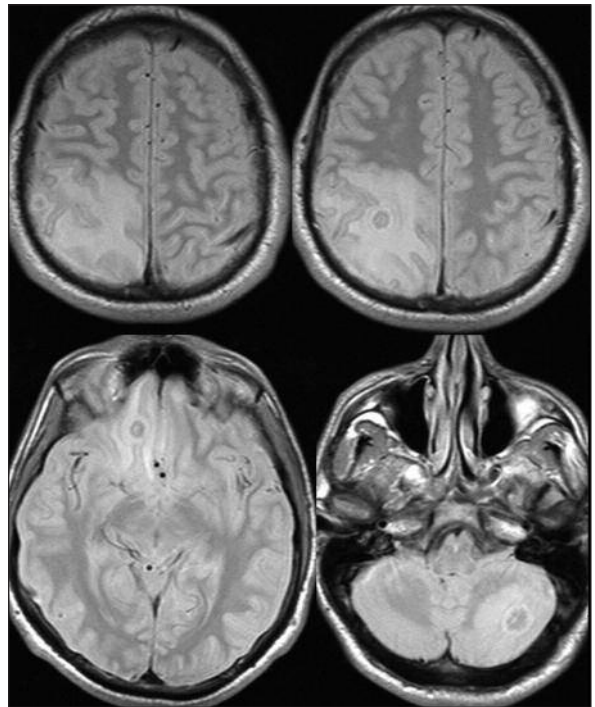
Brain MRI, in the left cerebellar hemisphere, in the localization of the right frontal lobe gyrus, medial and lateral parts of the right frontoparietal junction round total of 4 units, environmental style around enhancing mass lesions followed extensive white matter edema.
